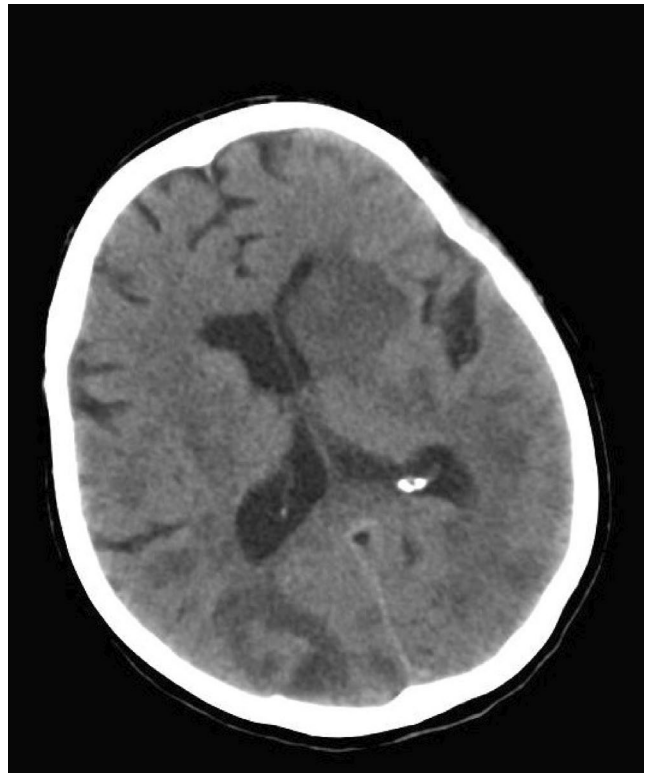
CASE 1 Noncontrast enhanced computed tomography demonstrating multiple hypodense lesions, most prominent in the left basal ganglia and right parietal lobe.
